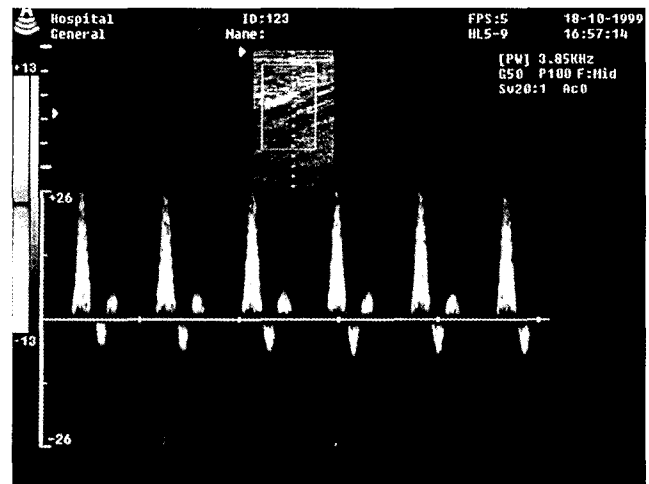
A doppler sonogram of a femoral artery. The velocity varies in a triphasic pattern during a cardiac cycle.
